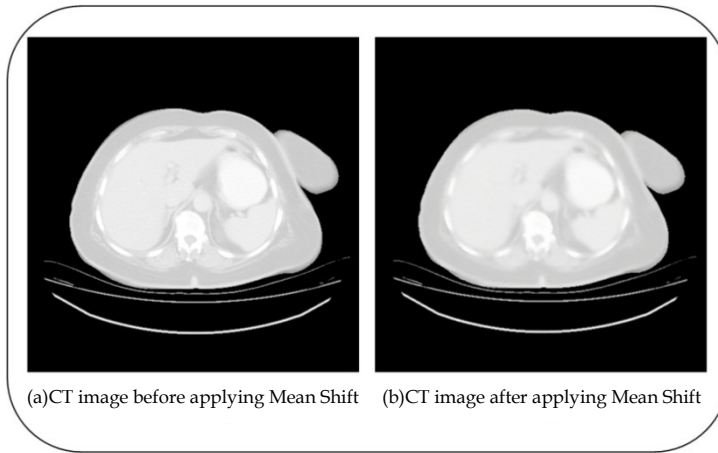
CT slice before and after Mean Shift smoothing
